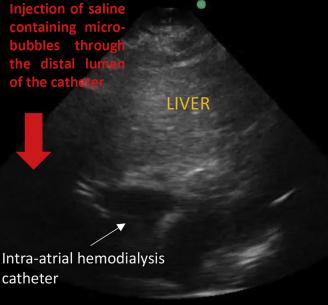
Ultrasound showing the presence of microbubbles immediately after the injection of saline air mixture, attesting to the intra-atrial position of the hemodialysis catheter (black arrow on frontal chest x-ray).
